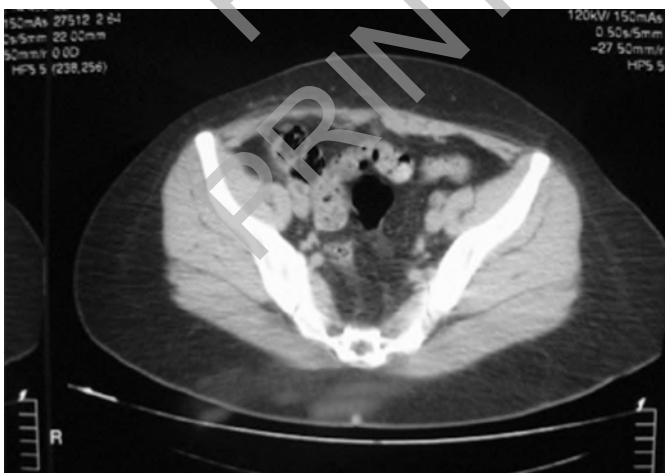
CT scan image after 1 year: note the absence of the right rectus abdominis muscle.
